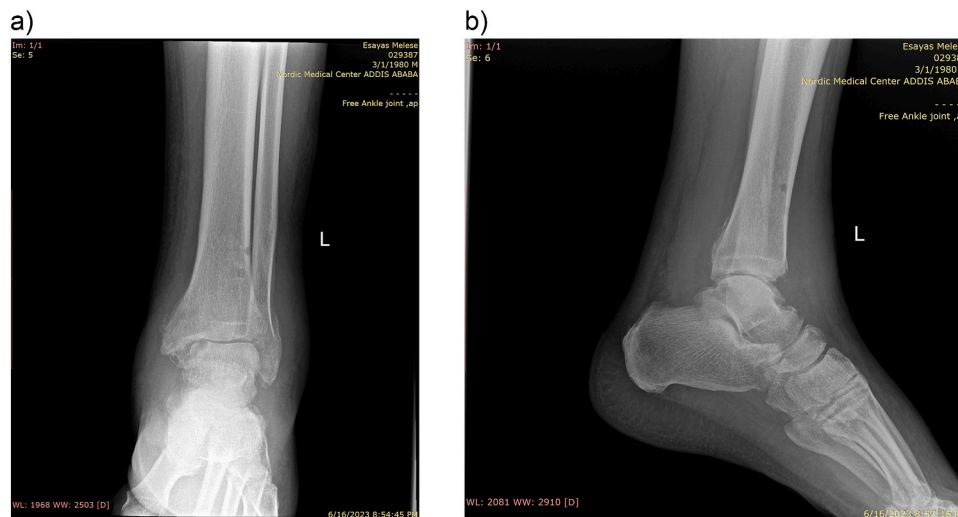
Last ankle X-ray obtained during follow-up, approximately two months after drainage of the ankle abscess, when ankle pain recurred. This X-ray demonstrated radiological worsening with increased joint space narrowing and more well-defined talar lucency. a) AP view. b) Lateral view.
